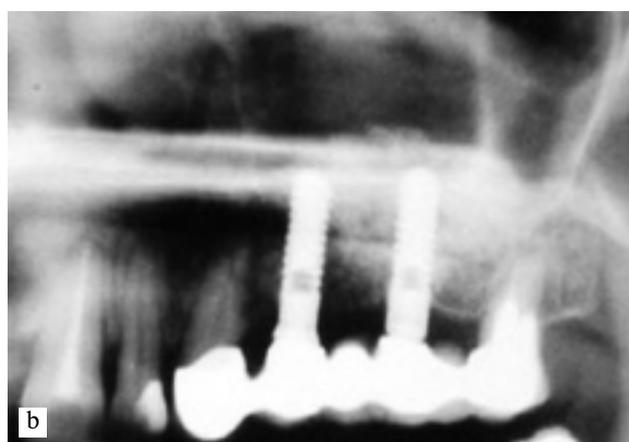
(a) Radiograph before the operation demonstrates insufficient bone height to place proper implant length. (b) Sufficient bone height to place 14 mm implant length after sinus lift operation.
